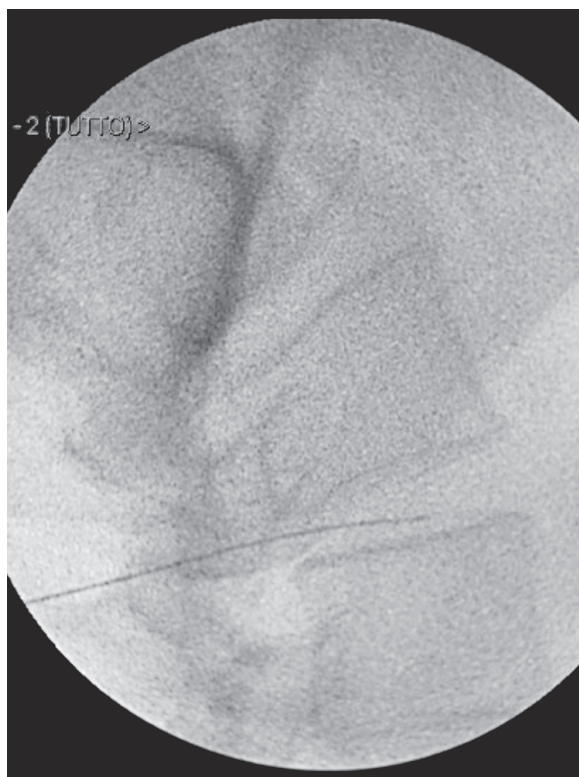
Lumbo-sacral spine x-ray in two orthogonal views to display the needle in an intradiscal position.
